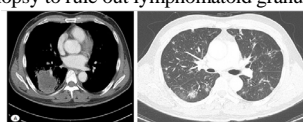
A) Chest CT image showing low attenuated RLL mass. B) Multiple irregular nodules with surrounding subtle GGO with some internal low density portion and open bronchus sign in both lungs.
